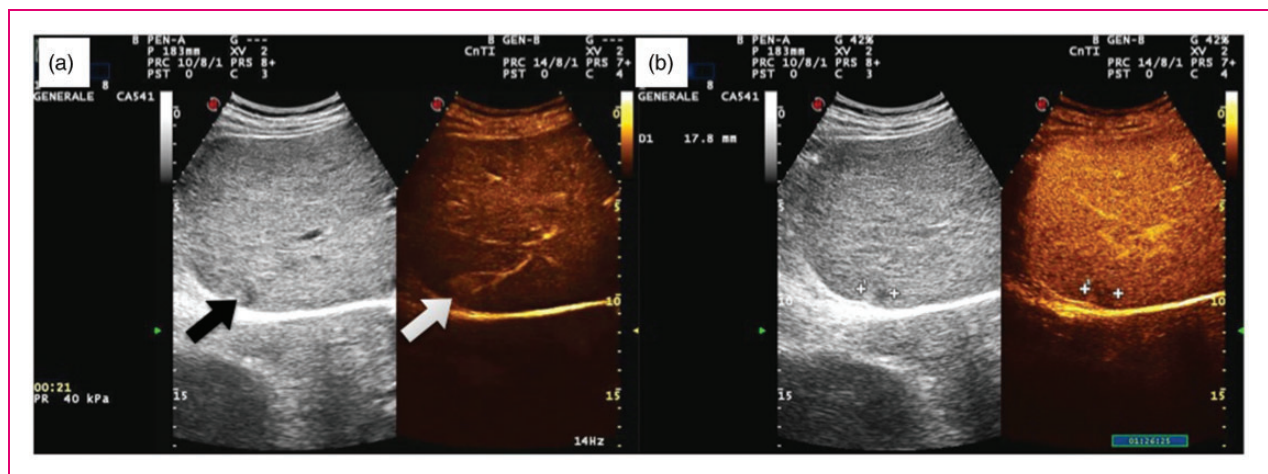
Contrast-enhanced appearance of a combined hepatocellular–cholangiocellular carcinoma (CHC) nodule at risk of misdiagnosis with typical hepatocellular carcinoma (HCC) on dual imaging with real-time contrast-enhanced ultrasound (CEUS) examination. (a) On the left, inhomogeneous subcapsular nodule in cirrhosis on B-mode ultrasound (black arrow). Subcapsular CHC in cirrhosis displaying a homogeneous arterial hyper-enhancement in CEUS (white arrow). (b) Wash-out of the nodule in the portal phase (1 min 26 sec post-injection).
